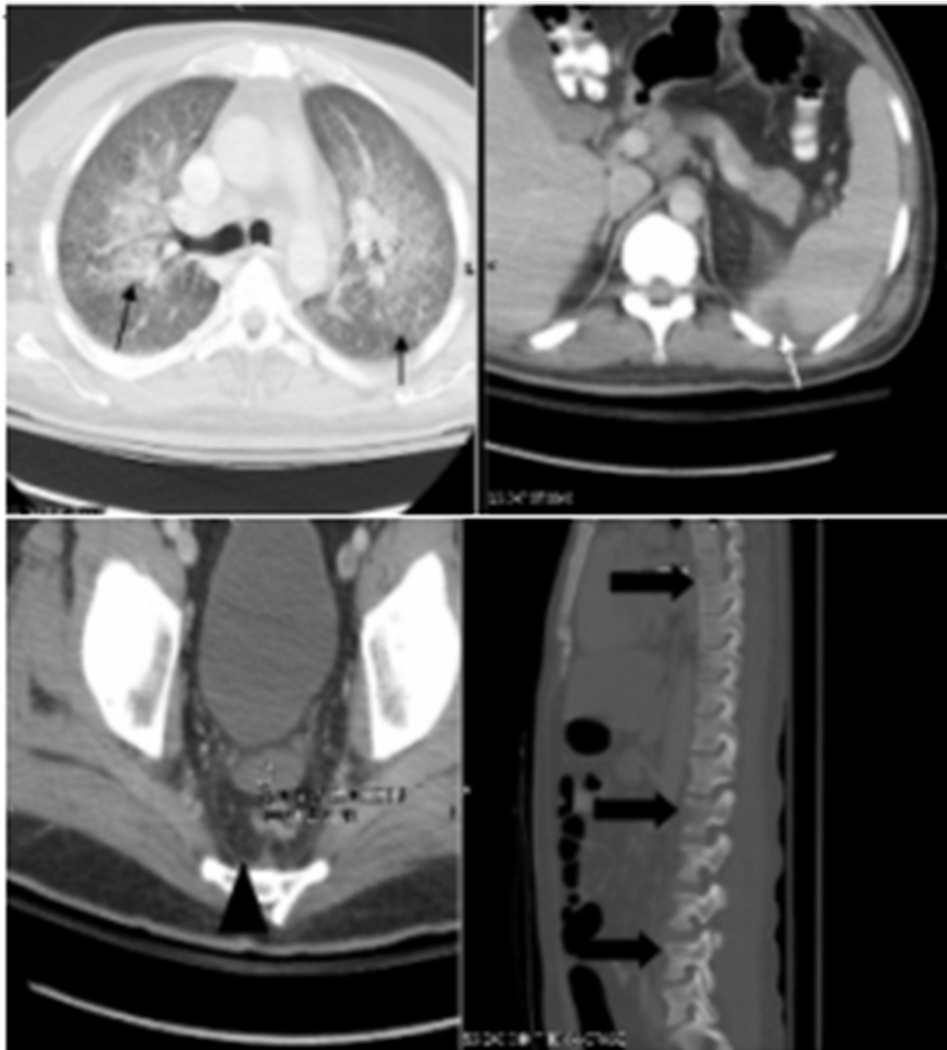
CT scan of the chest, abdomen, and pelvis. Peripheral ground-glass opacities in the lungs (thin black arrows). Peripheral wedge-shaped opacity in the spleen (white arrow). Free fluids in the rectovesical and left paracolic gutters with mesenteric stranding (arrow head). Multifocal osteolytic lesions involving the axial skeleton (thick black arrows).
